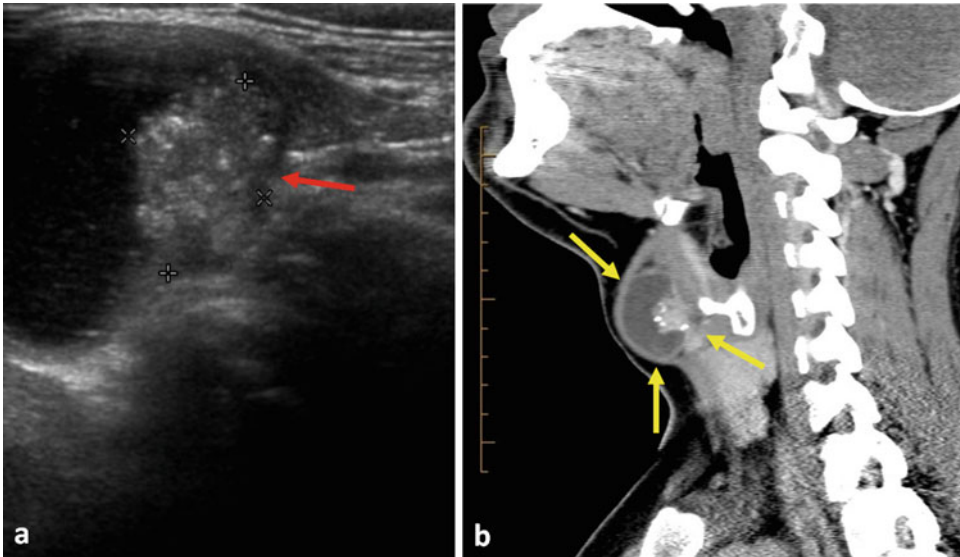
Papillary carcinoma in a thyroglossal duct cyst. Ultrasound of mass in the superior midline of the anterior neck showing cystic lesion with solid nodule containing microcalcifications (red arrow) (a). CT sagittal reconstruction shows midline anterior neck cyst elevating
